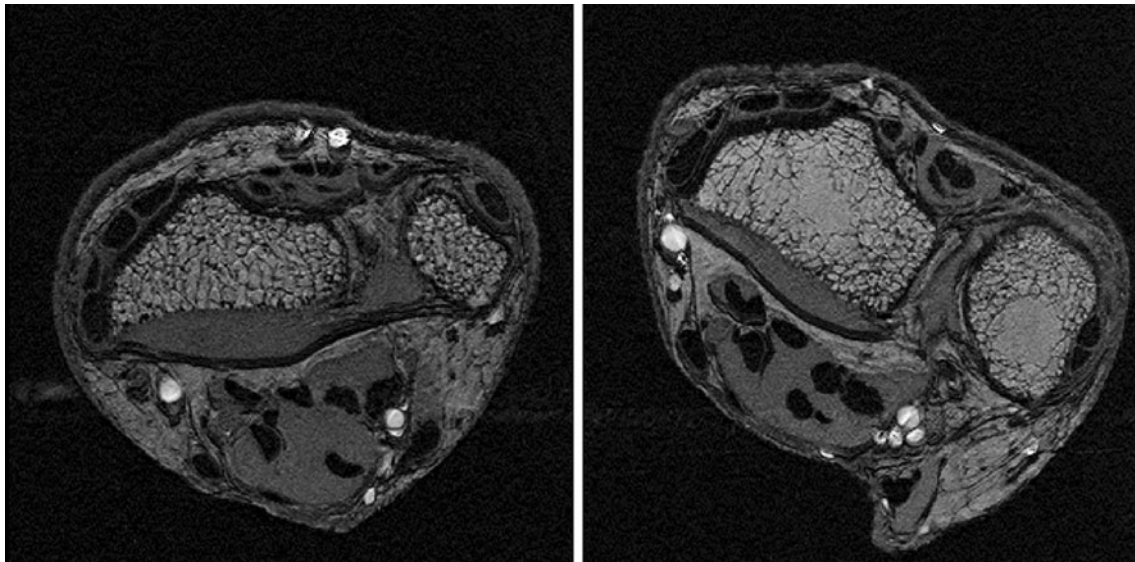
Representative MR images of the forearm of a healthy (*left*) and osteoporotic (*right*) patient acquired by using a three-dimensional gradient echo sequence (in-plane resolution $195 \times 195 \mu\text{m}^2$, axial slice thickness $500 \mu\text{m}$) at 1.5 T
